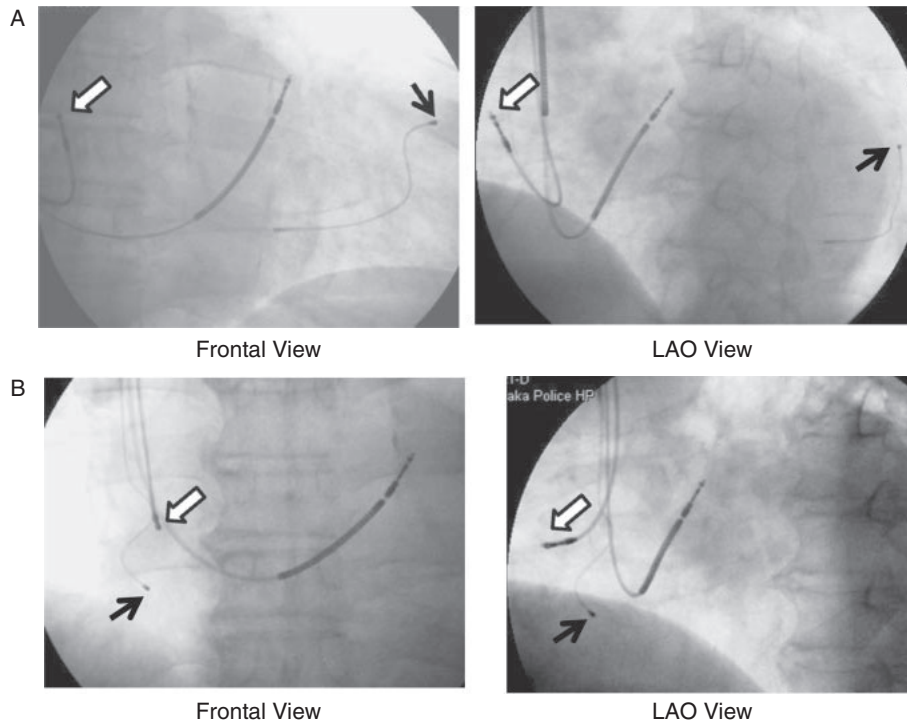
Radiographs obtained in the catheterization laboratory immediately after CRT-D implantation (A) and at re-hospitalization (B).
